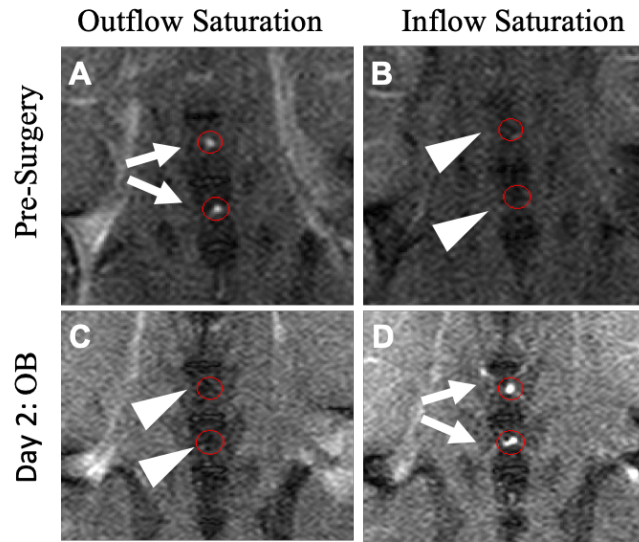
Sagittal MRI slices with saturation bands placed to saturate either outflow (veins bright) or inflow (outflow bright). Back branches flowing into the IVC prior to thrombus induction (A and B) reversed direction 2 days following IVC ligation when branches were left uninterrupted (C and D).
